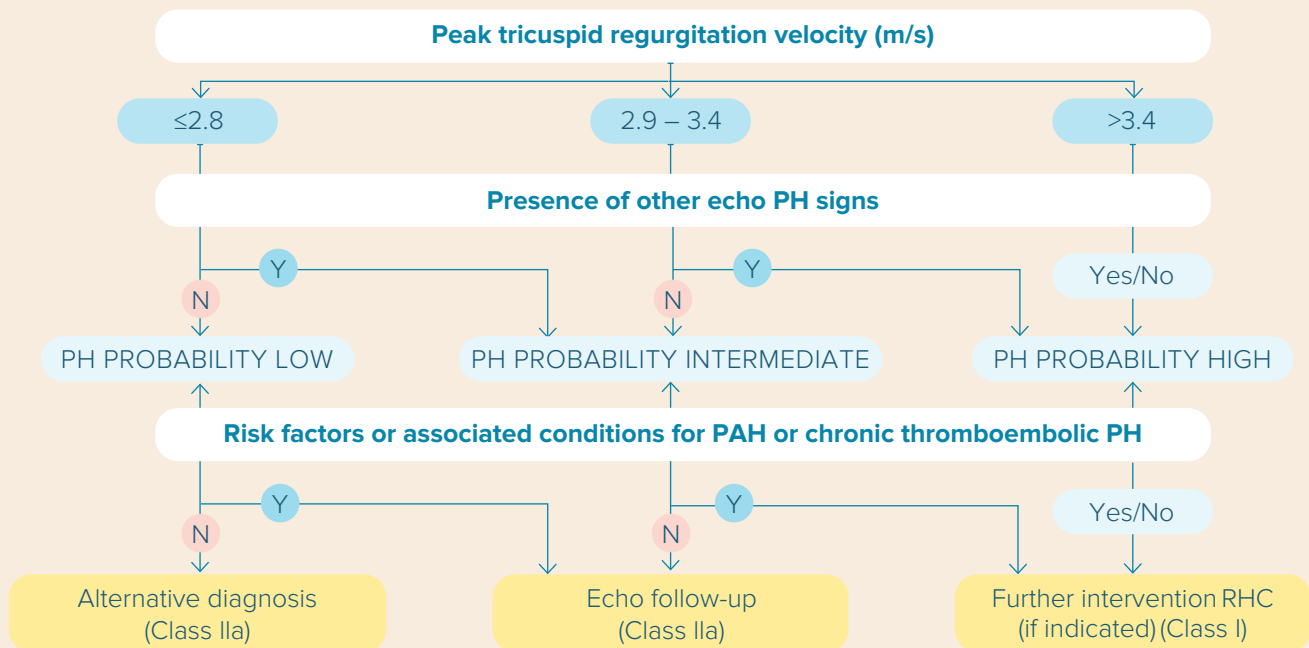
Echocardiographic probability of PH in symptomatic people with a suspicion of PH, and further assessment¹
